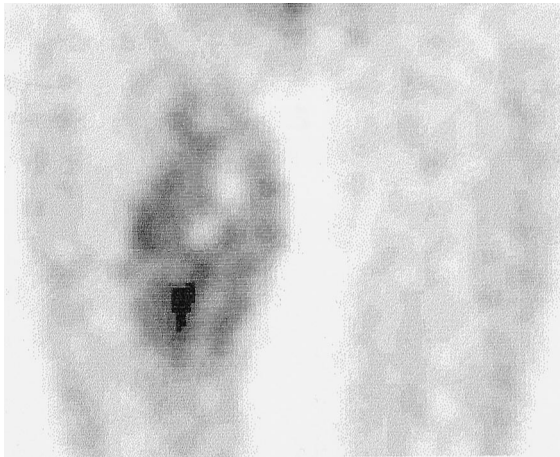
Coronal SPECT slice through the upper legs of patient 13 with a high-grade liposarcoma showing intense uptake of IMT. Heterogeneous uptake with a central defect is caused by necrosis.
